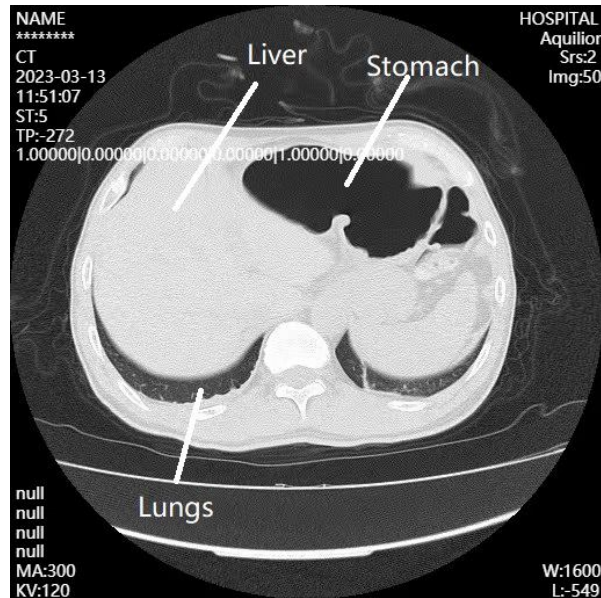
Chest CT 7 days after operation
